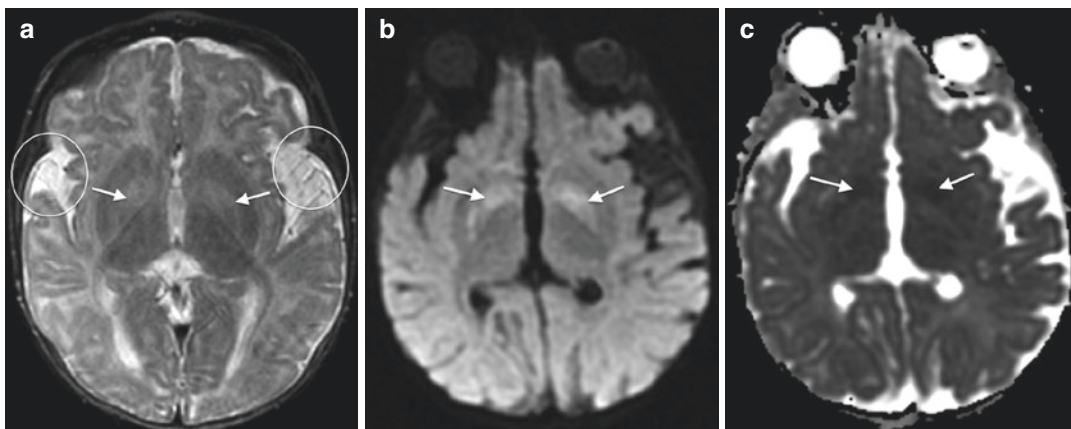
5-month-old male with glutaric aciduria type I. Axial T2WI (TR/TE ms, 3100/90) (a), DWI (TR/TE ms, 10,000/84) (b), and ADC (TR/TE ms, 10,000/84) (c) through the basal ganglia. Globi pallidi are abnormally hyperintense on T2WI (arrows, a) and demonstrate
